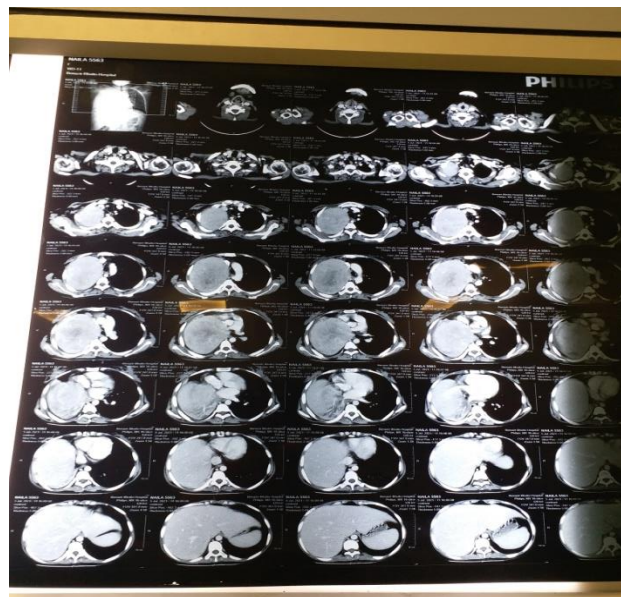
Pre op CT scan Chest
